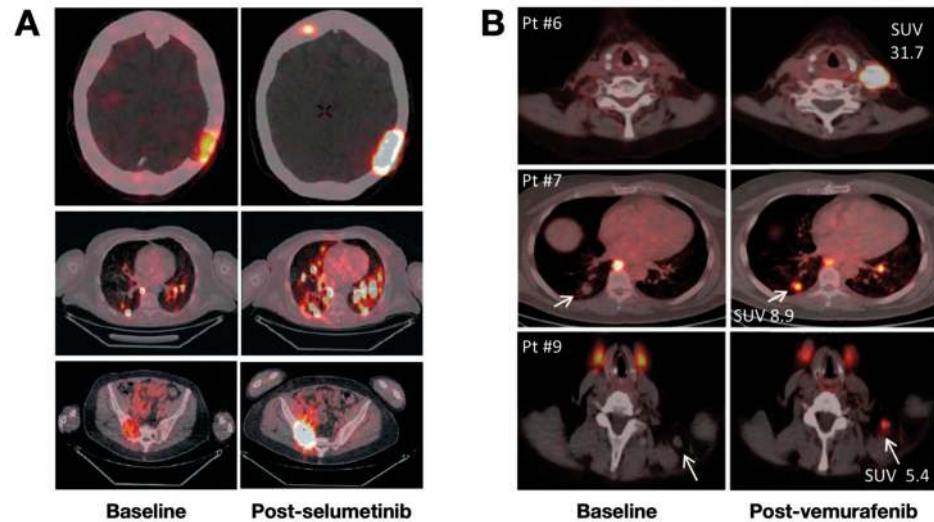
[^{124}I]NaI PET/CT images of patients with RR-DTC or PDTC with or without kinase inhibitors. (A) PET/CT images showed enhanced iodine uptake of lesions post-treatment with selumetinib in nearly all previously negative head, lung, and sacroiliac bone metastases. Reproduced with permission from [35], copyright 2013 Massachusetts Medical Society. (B) PET/CT images showed enhanced radioiodine uptake of lesions in the neck and lung after treatment with vemurafenib, a specific BRAF $^{\text{V600E}}$ inhibitor. Reproduced with permission from [36], copyright 2019 Endocrine Society.
